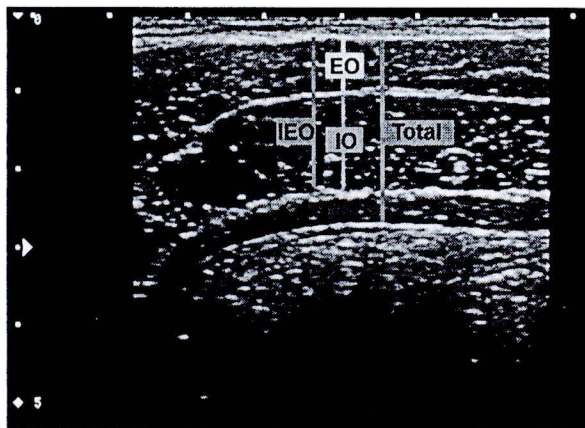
Ultrasound image of lateral abdominal muscles at rest. Muscle thickness of transversus abdominis (TrA), internal oblique (IO), external oblique (EO), internal and external oblique (IEO) and total of lateral muscles (Total) were measured from superior to inferior border of each muscle.
